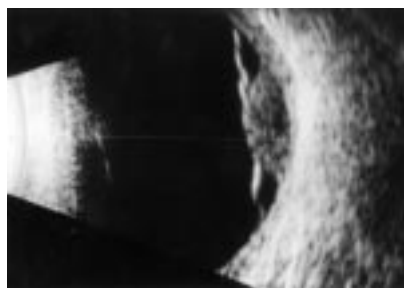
B-scan ultrasonogram showing an acoustically hollow choroidal mass with associated retinal detachment.
